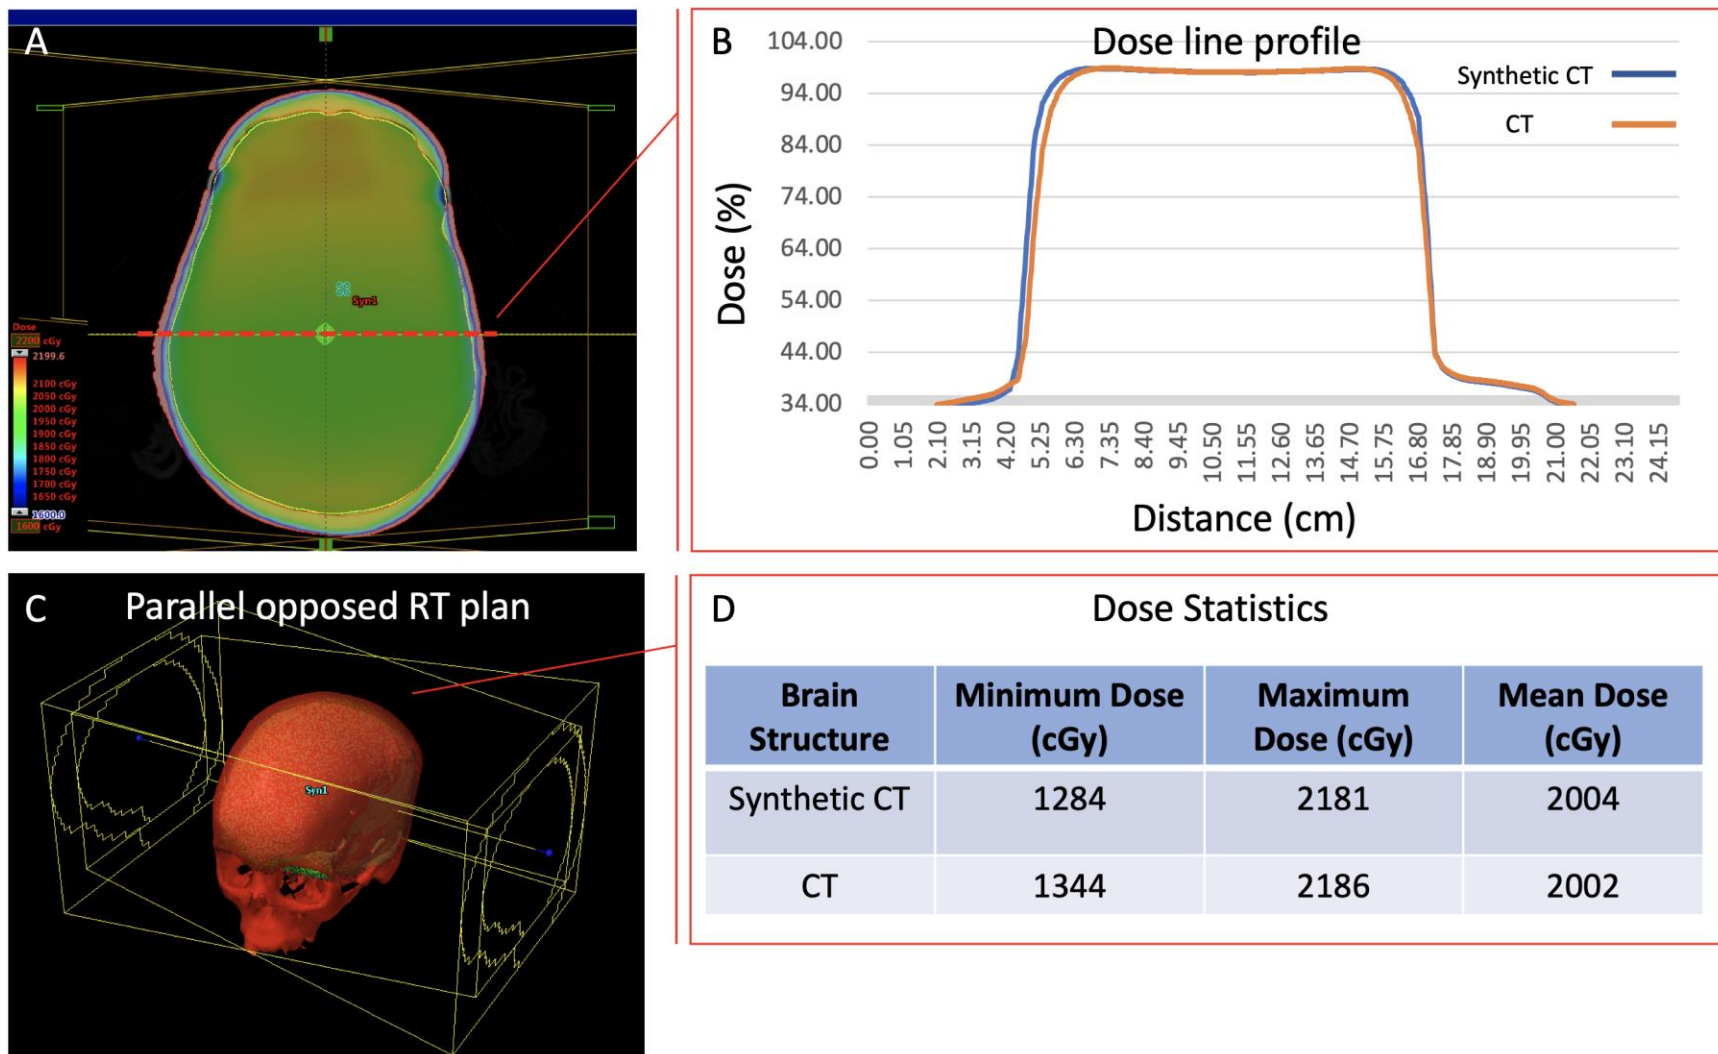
Comparison of the dose calculation between two radiation treatment plans using CT and FUSE-derived sCT.
